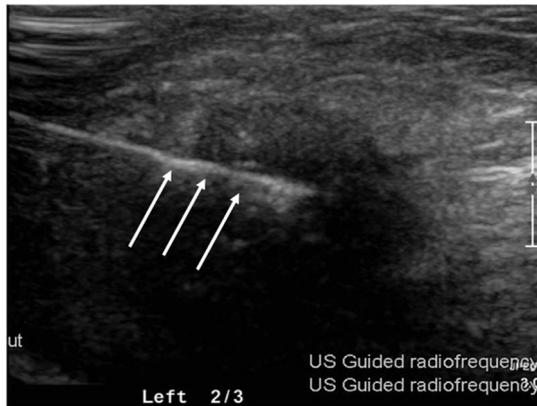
Ultrasound image of a Morton's neuroma with RFA needle within (arrows), introduced in-plane with the ultrasound probe.
